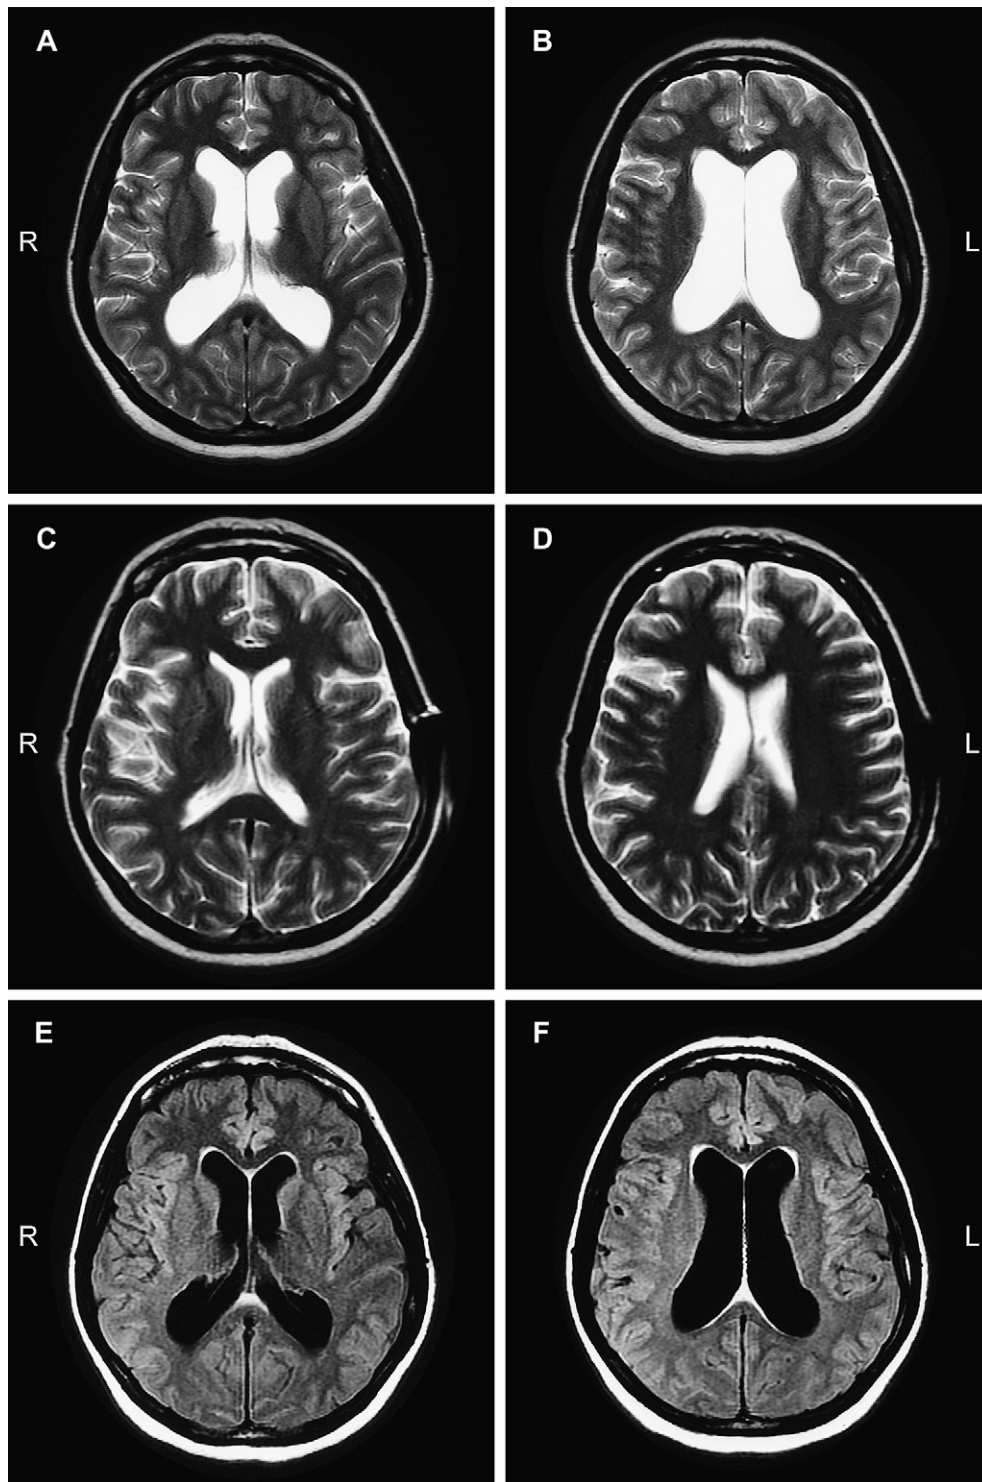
MRI axial T2-weighted supratentorial images disclosing signs of hydrocephalus before the operation (A–B) and normalisation of the ventricular volumes in the early postoperative phase after shunting (C–D). Preoperative MRI axial T2-weighted supratentorial FLAIR slices did not disclose periventricular high signal lesions, excluding important intracranial hypertension in the presence of hydrocephalus (E–F).
